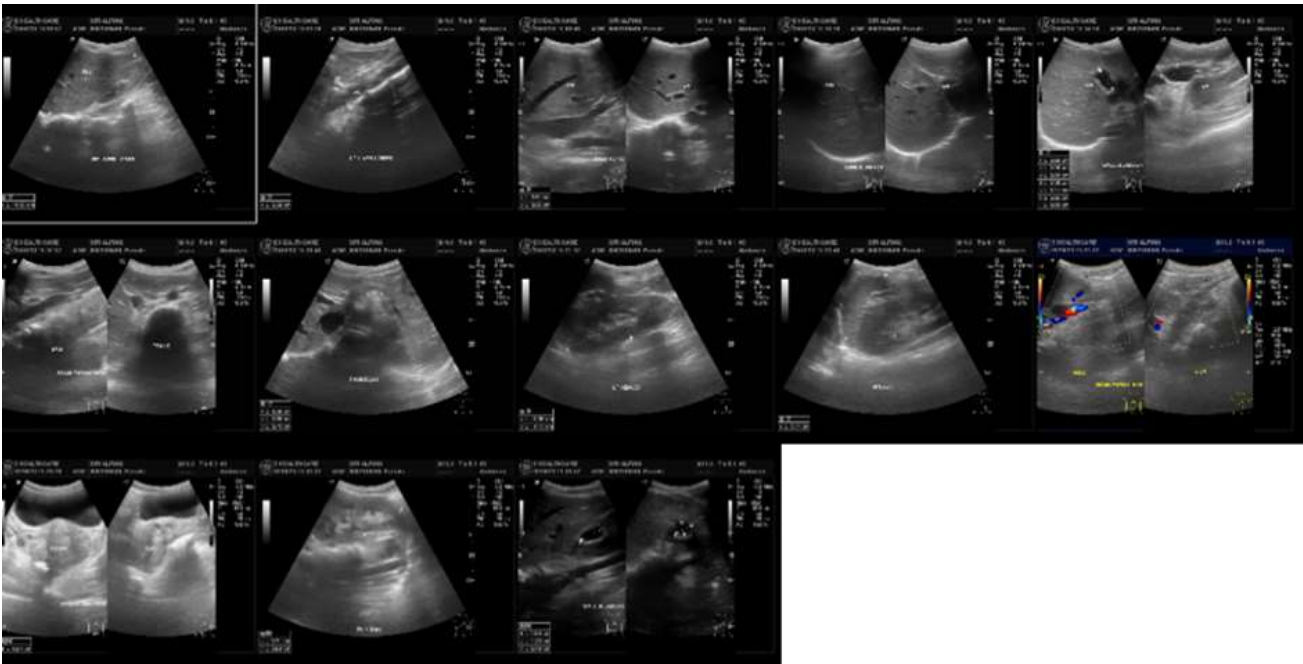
Abdominal ultrasound results.
